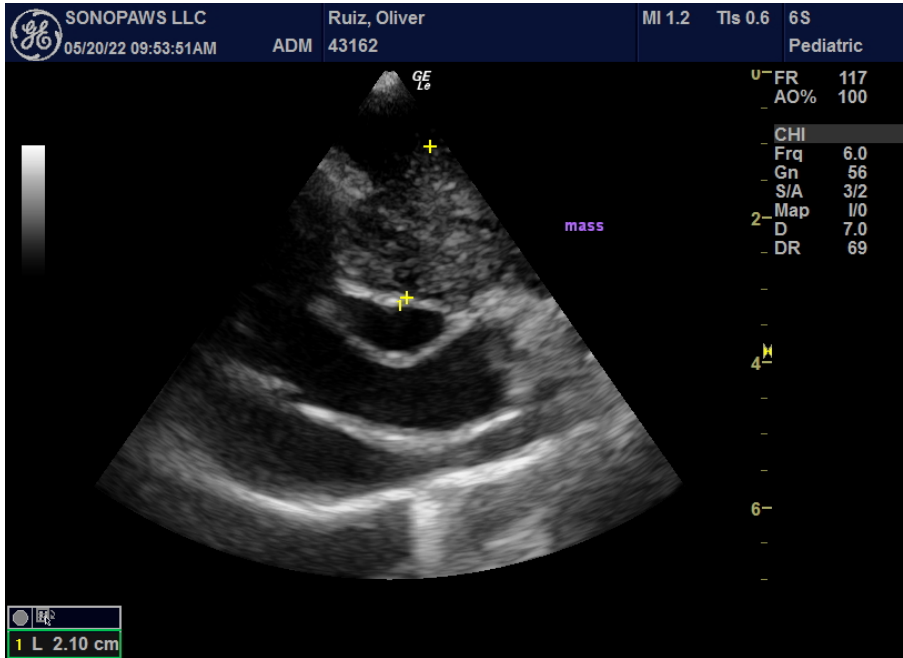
Left parasternal long axis view. The mass measures 2.1cm wide near the aorta.
